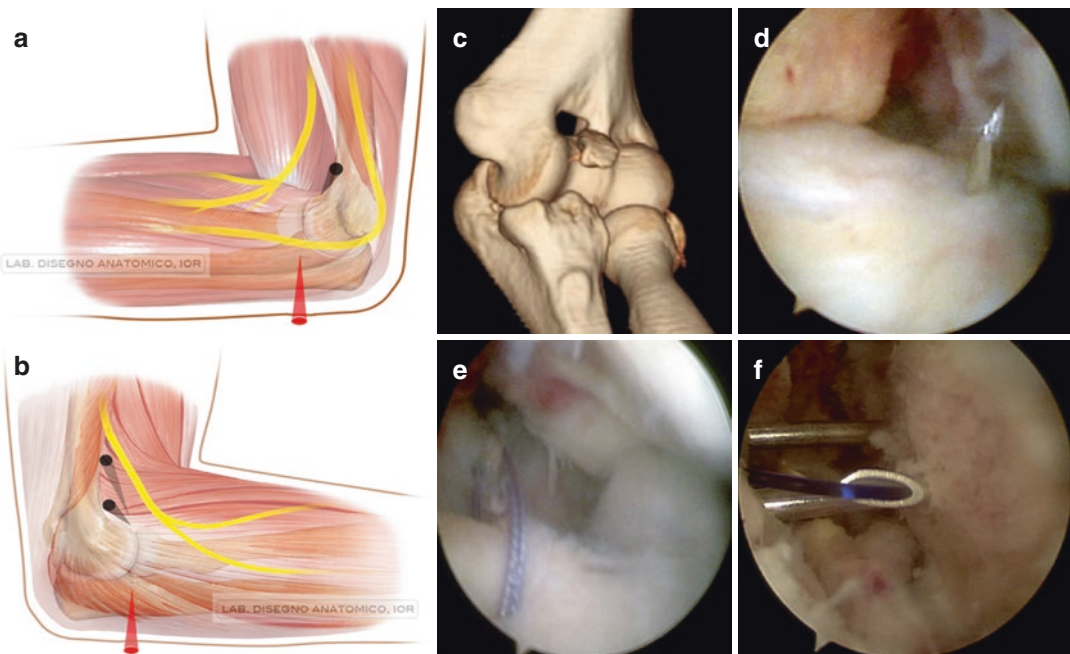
Osteosuture of a coronoid fracture. The portals to perform osteosuture are the same as for K wires or screw fixation (a, b). Preoperative CT scan (c) shows a displaced fracture, suggesting joint derangement. By
